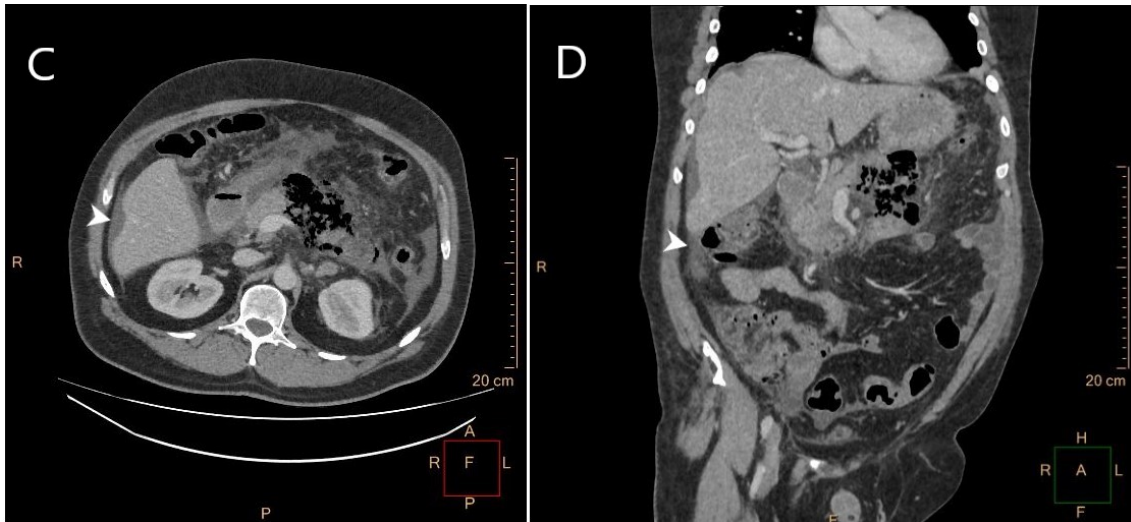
Abdominal CT with intravenous contrast in portal phase shown in axial (C) and coronal (D) views, a rarefaction of peripancreatic fat, and presence of free perihepatic fluid (white arrow) in the root of the mesentery and in both paracolic gutters, all in relation to inflammatory changes. These findings suggested the initial diagnosis of emphysematous pancreatitis.
